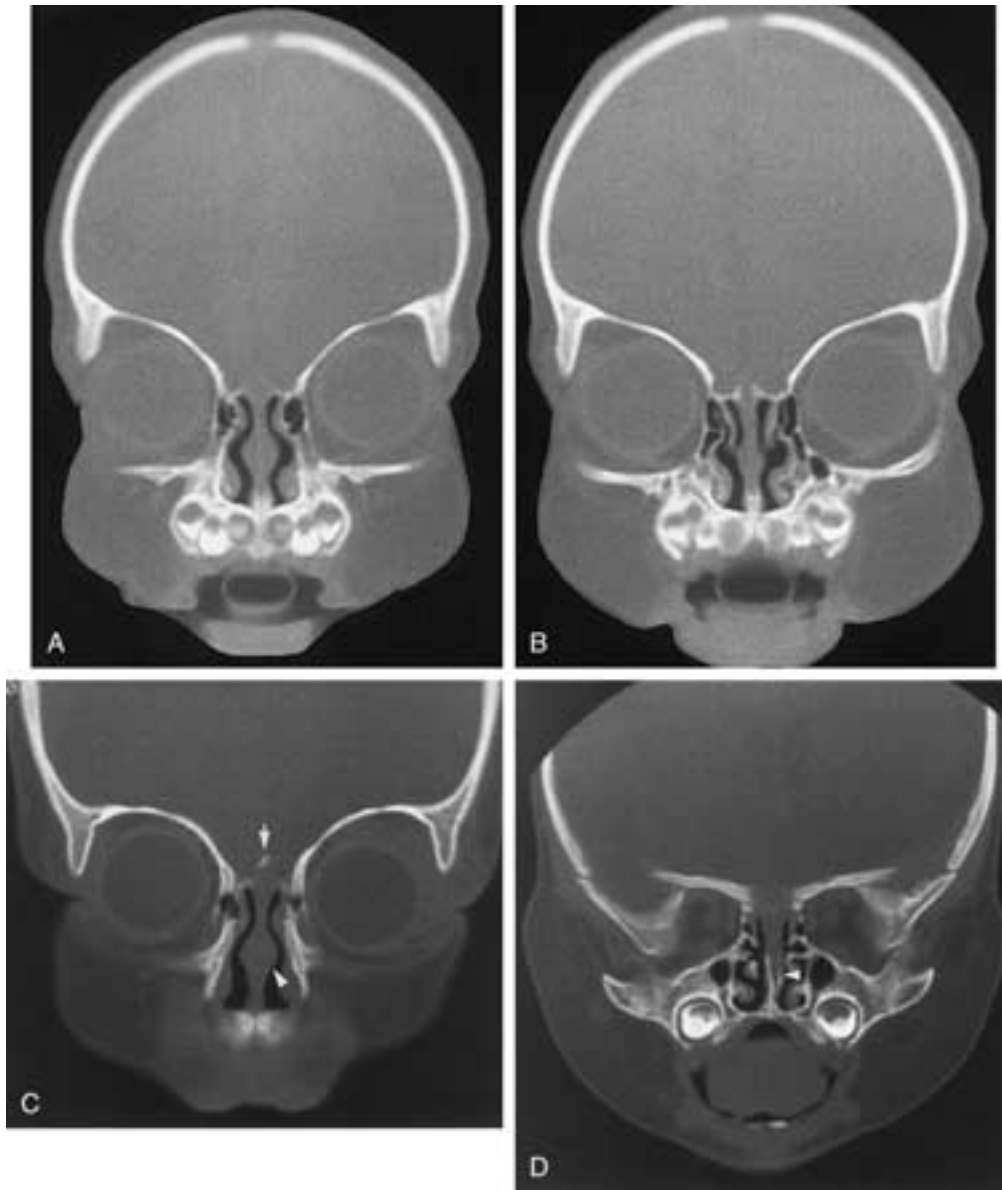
Normal patterns of ossification of the nasal capsule, as shown by direct coronal CT in progressively older patients. A and B, Four-month-old girl. The lateral ethmoid centers and a small segment of vomer are ossified. The midline septal cartilage is entirely unossified. C and D, Five-month-old boy. The lateral ethmoid centers, the palatal shelves, the vomer, and the tip (*white arrow*) of the crista galli are ossified. The widened midportion of the septum (*white arrowhead* in C) is designated the septal diamond. The two sides of the vomerine groove give the posterior septum a bilaminar appearance (*white arrowhead* in D).
